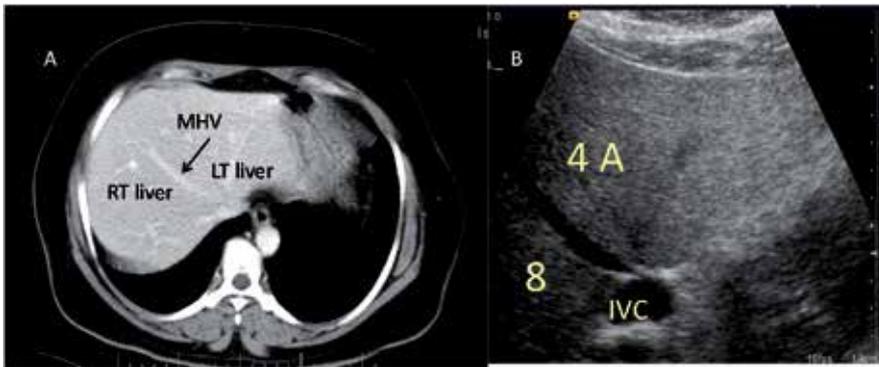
Middle hepatic vein (MHV) A) CT B) Ultrasound
